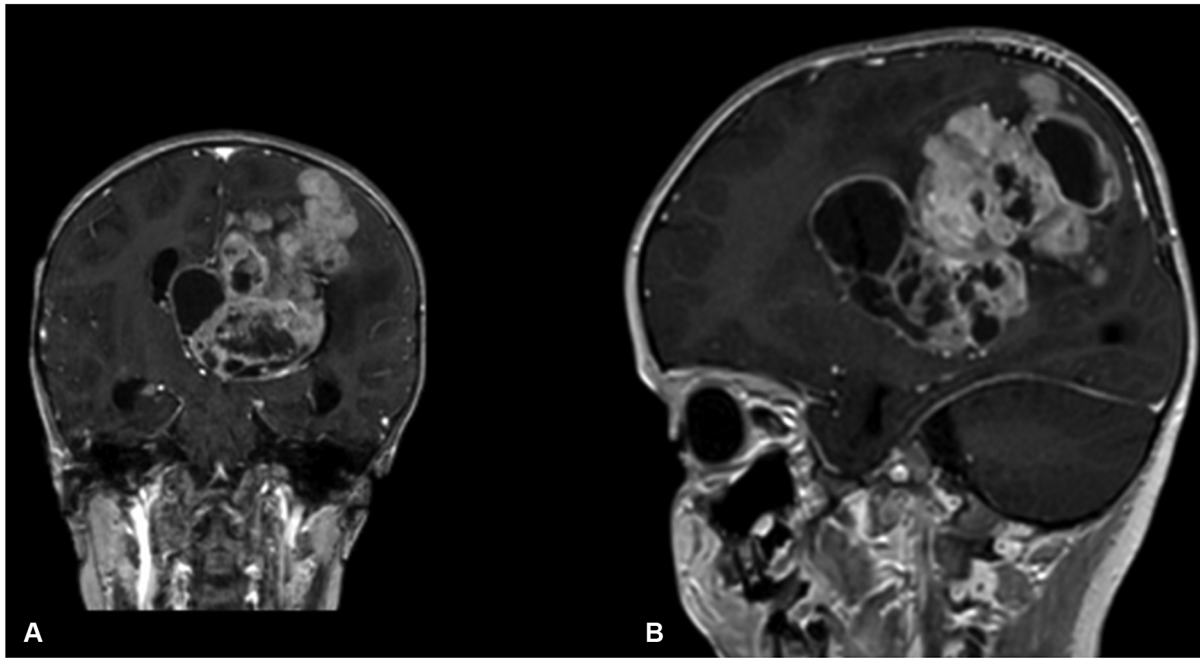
Radiologic findings revealed on MRI T1-weighted contrast-enhanced coronal and sagittal images and T2-weighted axial image showing a well-circumscribed solid and cystic lesion with little perilesional edema. The solid and cystic lesion was hypo- to hyper-intense to gray matter on T1-weighted contrast-enhanced image (A, B).
